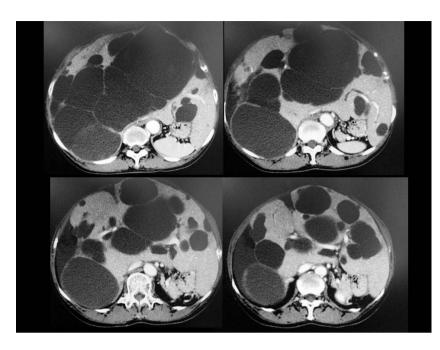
Abdominal CT findings before combined hepatectomy and cyst fenestration. Right posterior section of the liver was almost totally replaced by the cysts, and a major part of the right anterior section and left medial section was filled with cysts. However, the left lateral section was not affected as much by the cysts. The type of polycystic liver disease in the present case was classified in type II of Gigot's classification, grade 4 of Qian's classification, and type C of Schnelldorfer's classification.
